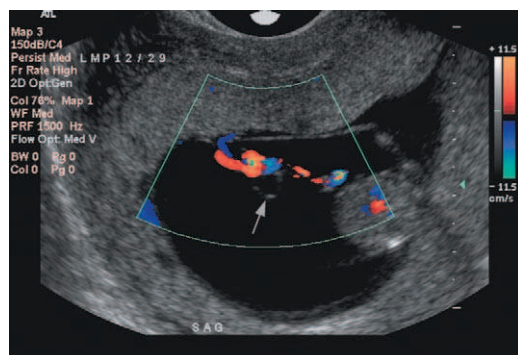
Longitudinal view of umbilical cord from a scan at 11 weeks' gestation. Color Doppler image delineates a 3-mm umbilical cord cyst (arrow). Sonographic follow-up showed resolution of the cyst. The baby was normal at delivery.
